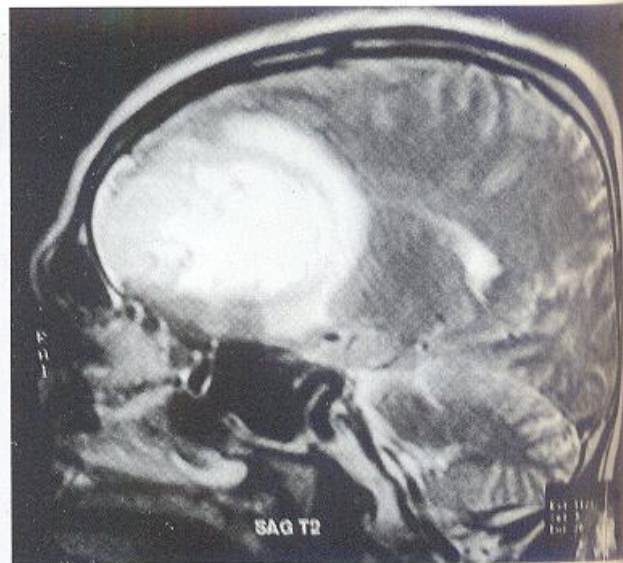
MRI showing glioma brain
